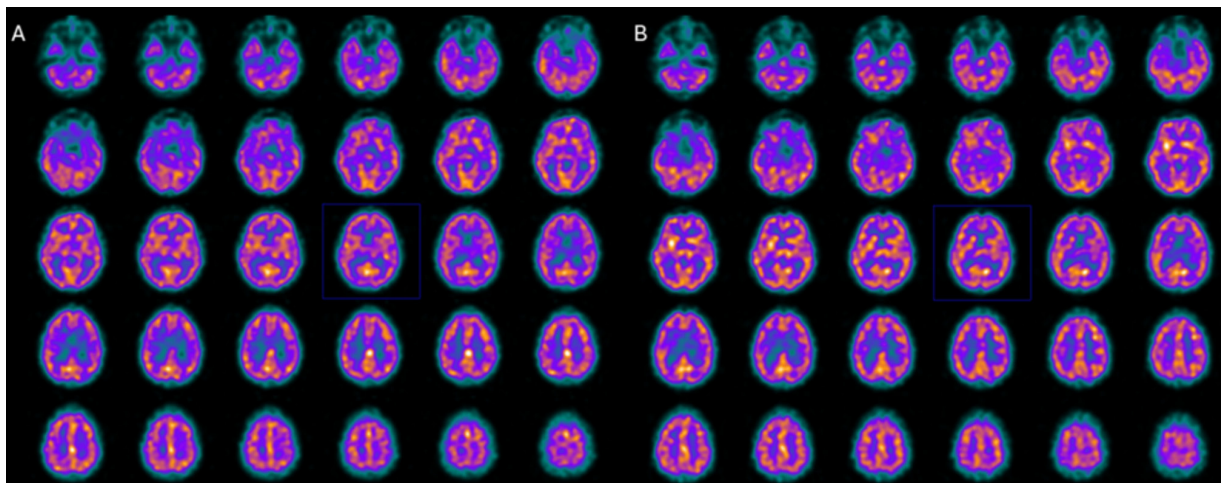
Perfusion SPECT images before (A) and after (B) hr-NGF administration. A, ^{99m}Tc-HMPAO SPECT images (transaxial slices) before hr-NGF treatment showed a mild reduction in radiotracer uptake (hypoperfusion) in the right and left caudate nucleus, right putamen, right and left thalamus. B, After hr-NGF treatment, a slight increase in ^{99m}Tc-HMPAO uptake was detected in the right caudate nucleus (+8%), left caudate nucleus (+7%), right putamen (+10%), right and left thalamus (+8%, respectively).
